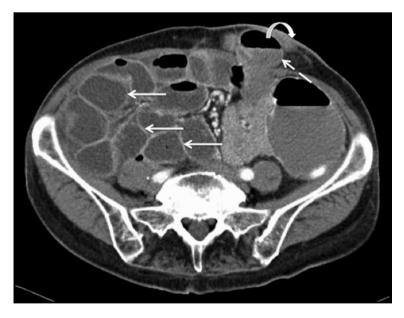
A 66-year-old woman with a prior colectomy for colorectal cancer presents with severe abdominal pain, vomiting, no output from her stoma and an irreducible parastomal hernia on exam. Axial contrast-enhanced CT abdomen/pelvis demonstrates dilated, fluid-filled small bowel loops (solid arrows). There is a point of transition from dilated proximal small bowel loops to collapsed distal small bowel loops at the level of a parastomal hernia in the left iliac fossa. Note the dilated small bowel loop in the left anterior abdominal wall (dashed arrow) adjacent to the stoma, which communicates with the skin (curved arrow)
